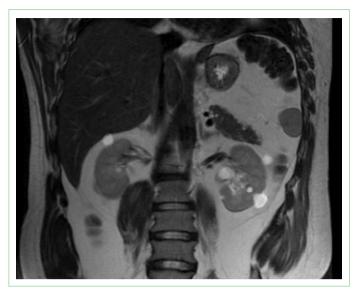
M.Y. contrast-enhanced abdominal MRI (29.05.2023).
